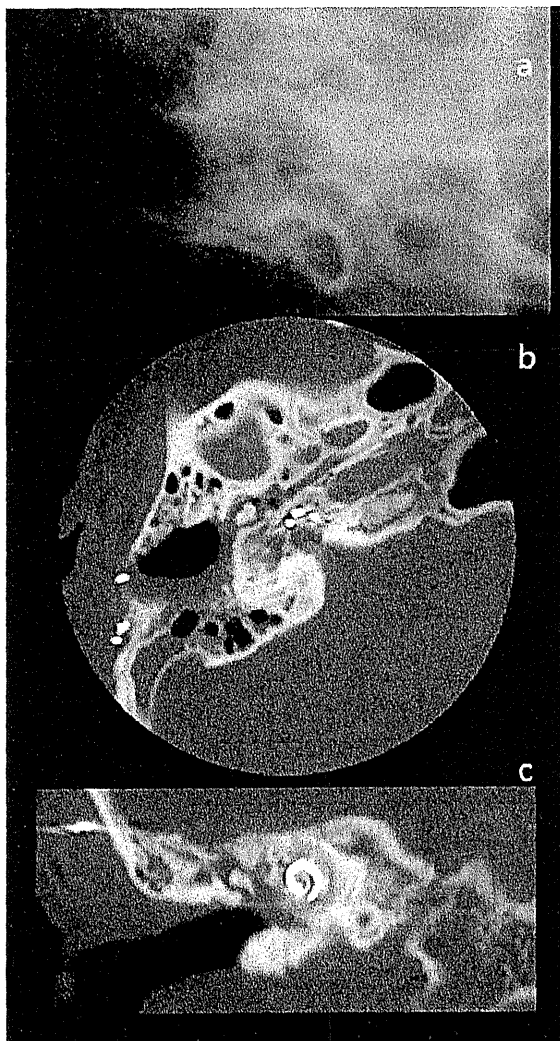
Intraoperative radiograph and postoperative HRCT images of the cochlea. Intraoperative radiograph (a) and postoperative HRCT images (b and c) showed fully inserted electrodes.
